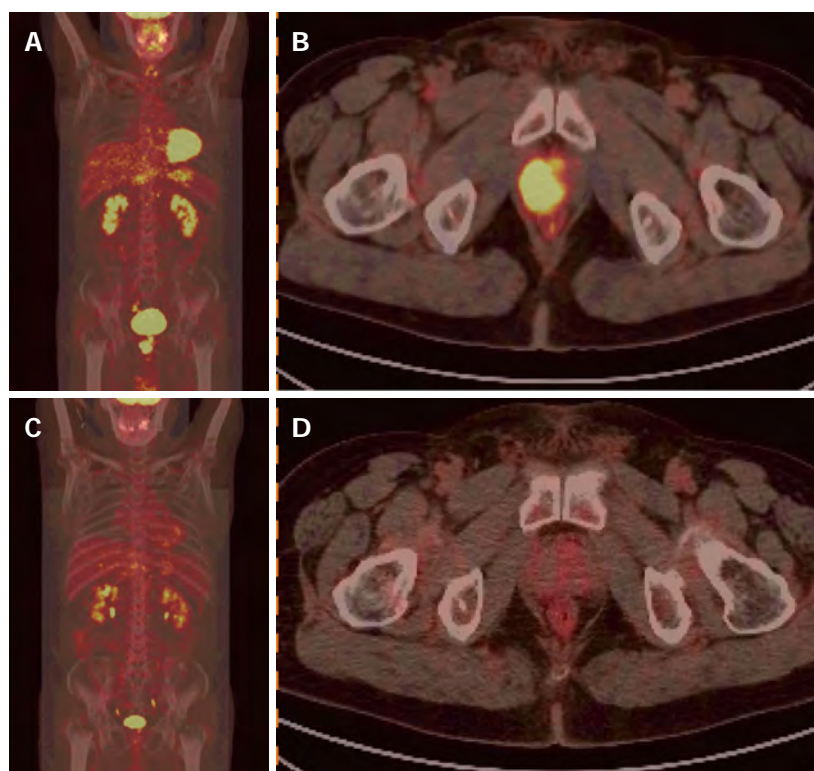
Positron emission tomography/computerized tomography image. A: Whole body positron emission tomography (PET) image (scan) shows nodal hypermetabolic foci in the prostate, and no abnormally high uptake foci in the other sites of the body; B: The PET/computerized tomography (CT) fusion image displays a nodal hypermetabolic lesion located in the right lobe of the prostate, with maximal standardized uptake value (SUV) being 12.7; C: There were no hypermetabolic foci on the whole body PET imaging following six courses of chemotherapy; D: There was complete remission of the prostatic lesion after six cycles of chemotherapy, and the maximal SUV was 2.0.
